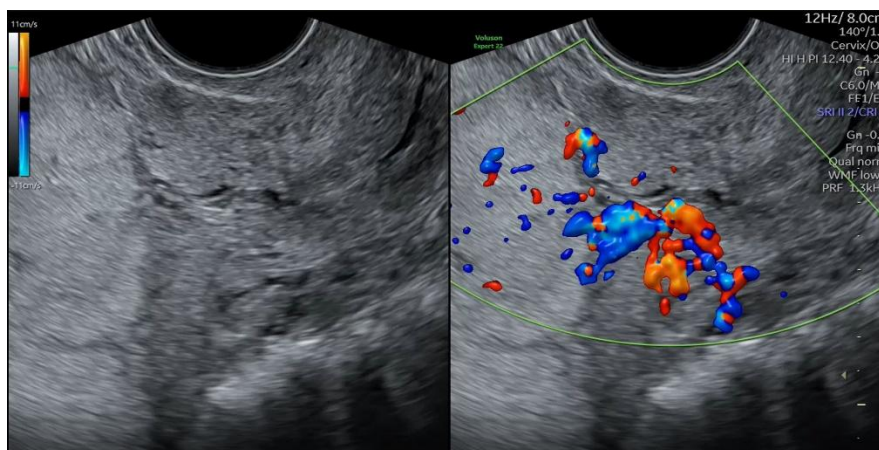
Colour doppler ultrasound highlighting abnormal vascularity typical of PAS.
